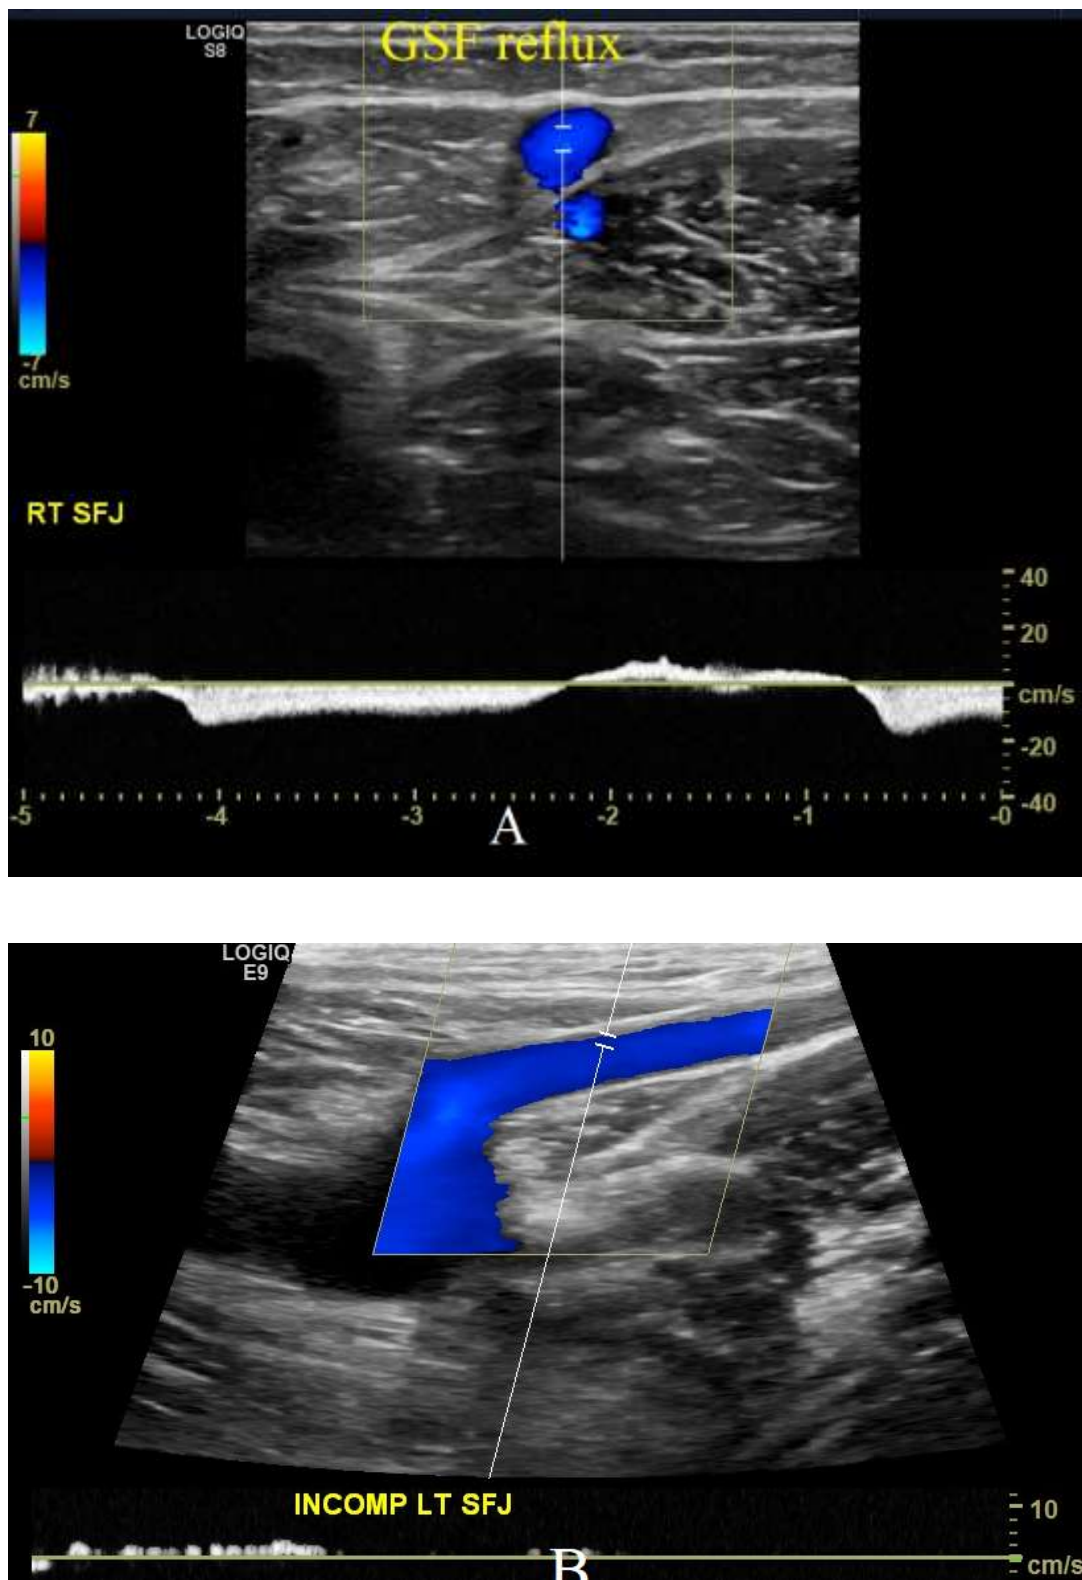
A-B Color Doppler ultrasound: Incompetent left saphenofemoral junction. Axial (A) and longitudinal (B) images.
